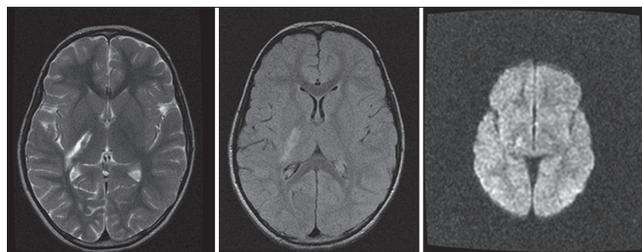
MRI brain T2 (left) showed increase signal at lower part of internal capsule. Same finding at T1 MRI brain (right). At the bottom DWI shows restriction diffusion same area suggest focal stroke
